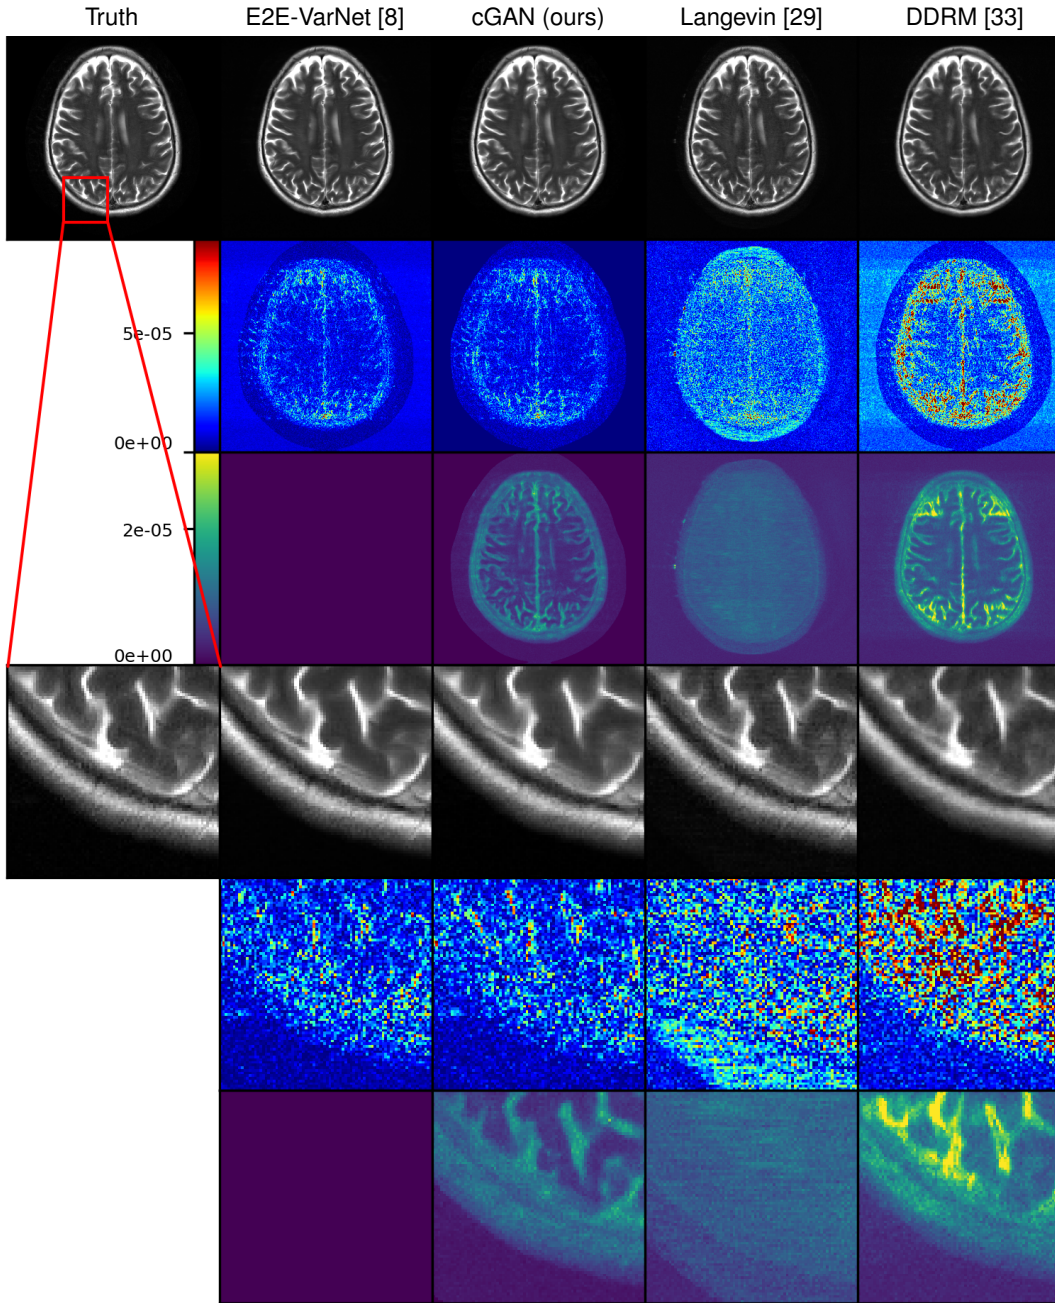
Example $R = 4$ MRI reconstructions with $P = 4$. Rows 1 and 4: P -sample average $\hat{\mathbf{x}}_{(P)}$. Rows 2 and 5: pixel-wise absolute error $|\hat{\mathbf{x}}_{(P)} - \mathbf{x}|$. Rows 3 and 6: pixel-wise SD $(\frac{1}{P} \sum_{i=1}^P (\hat{\mathbf{x}}_i - \hat{\mathbf{x}}_{(P)})^2)^{1/2}$. Rows 4 through 6 show a zoomed region.
